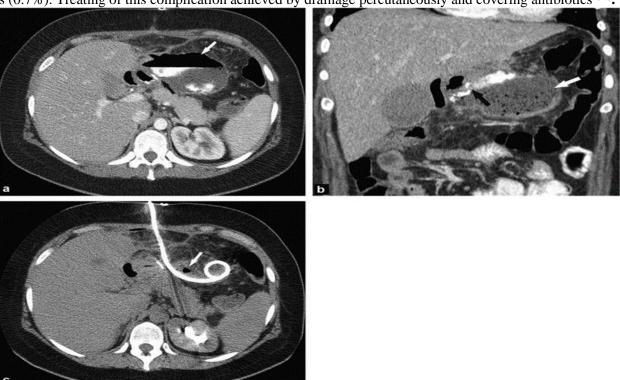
Leak near the lower staple line causing an abscess. A: The axial CT image showed a large collection of fluid with air and fluid level (white arrow) containing contrast close to the staple line in the upper abdomen. B: Abscess and leaking staples on a coronal CT scan (black arrow). C: Axial CT scan demonstrating improvement following draining of an abscess ⁽¹⁹⁾.
